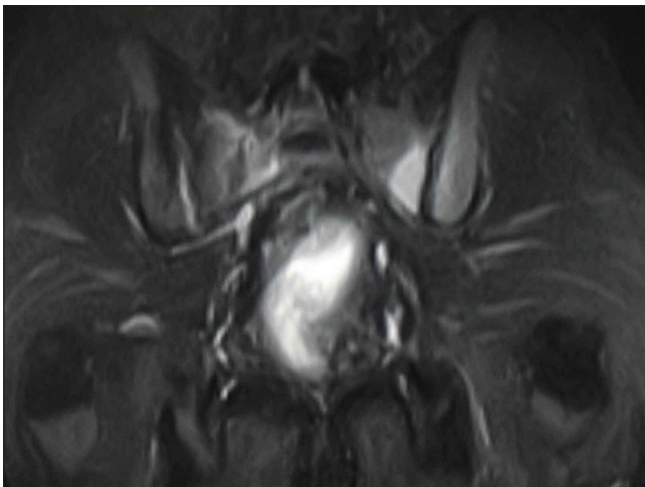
MRI showing altered signal around left sacroiliac joint
